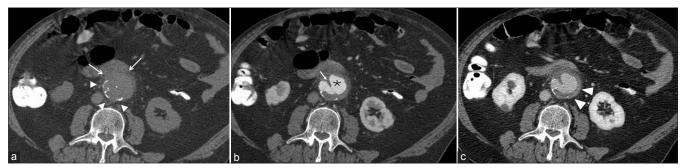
Unenhanced (a), arterial (b), parenchymal (c) axial CT. (a) There is periaortic fat stranding (white arrowheads). The fat plane between aorta and the duodenum is indistinct (white arrows). (b) The aortic lumen is irregular (black asterisk) with an internal flap (white arrow). (c) There is enhancement of the aortic wall (white arrowheads)
